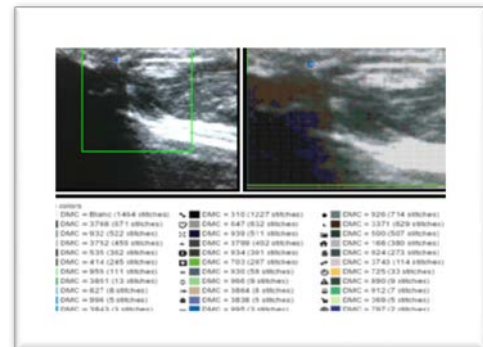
Decreased vascularity was detected in colour Doppler imaging compared to 7 day duration
